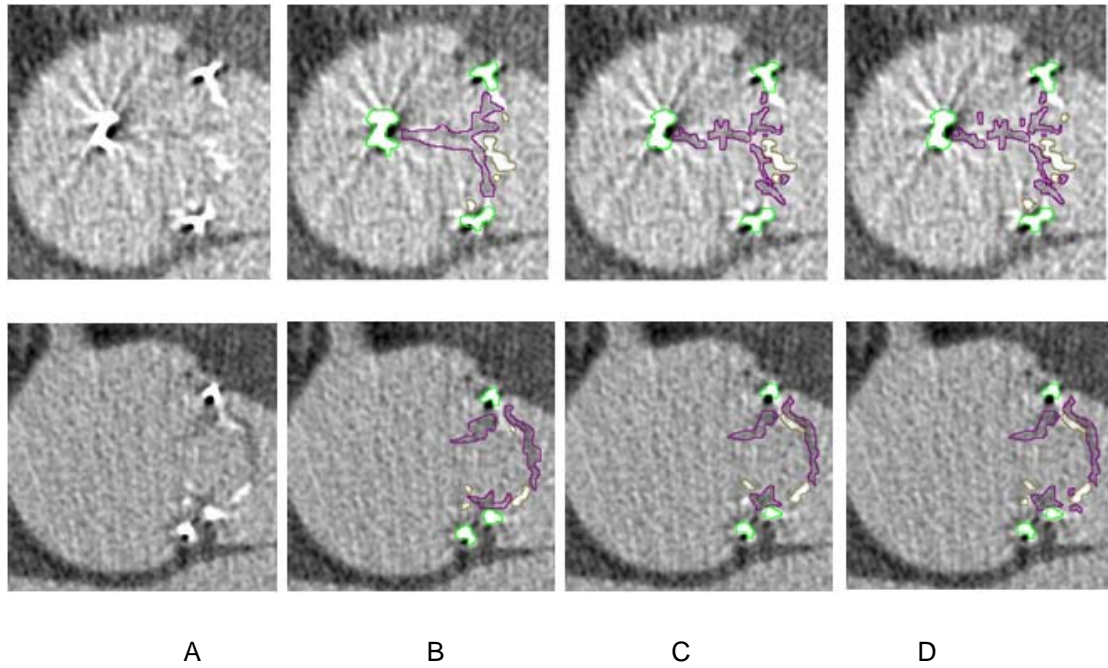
Examples of segmented CT-Slices obtained in case 2 - MAG. Original slices (A), results of segmentation performed by IRG (B), Stick RG (C) and SES (D). Metallic stent, calcifications and leaflets are indicated by green, brown and purple border respectively
